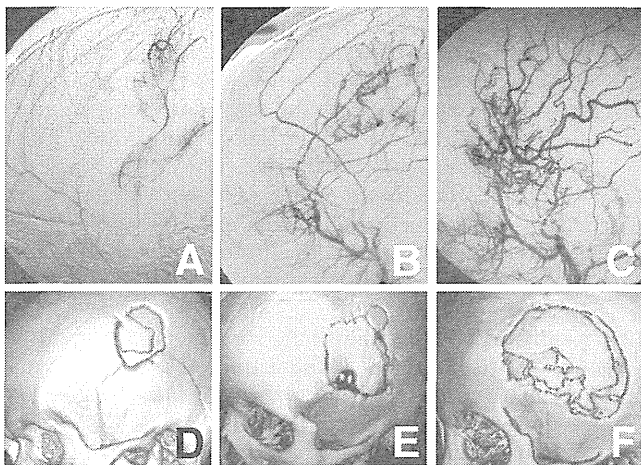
Postoperative external carotid angiograms (A-C) and three-dimensional skull computed tomography scans (D-F) showing the relationship between craniotomy size and the extent of surgical collaterals through indirect bypass after encephalo-duro-arterio-synangiosis (A, D), encephalo-myo-synangiosis (B, E), and encephalo-duro-arterio-myo-synangiosis (C, F).
